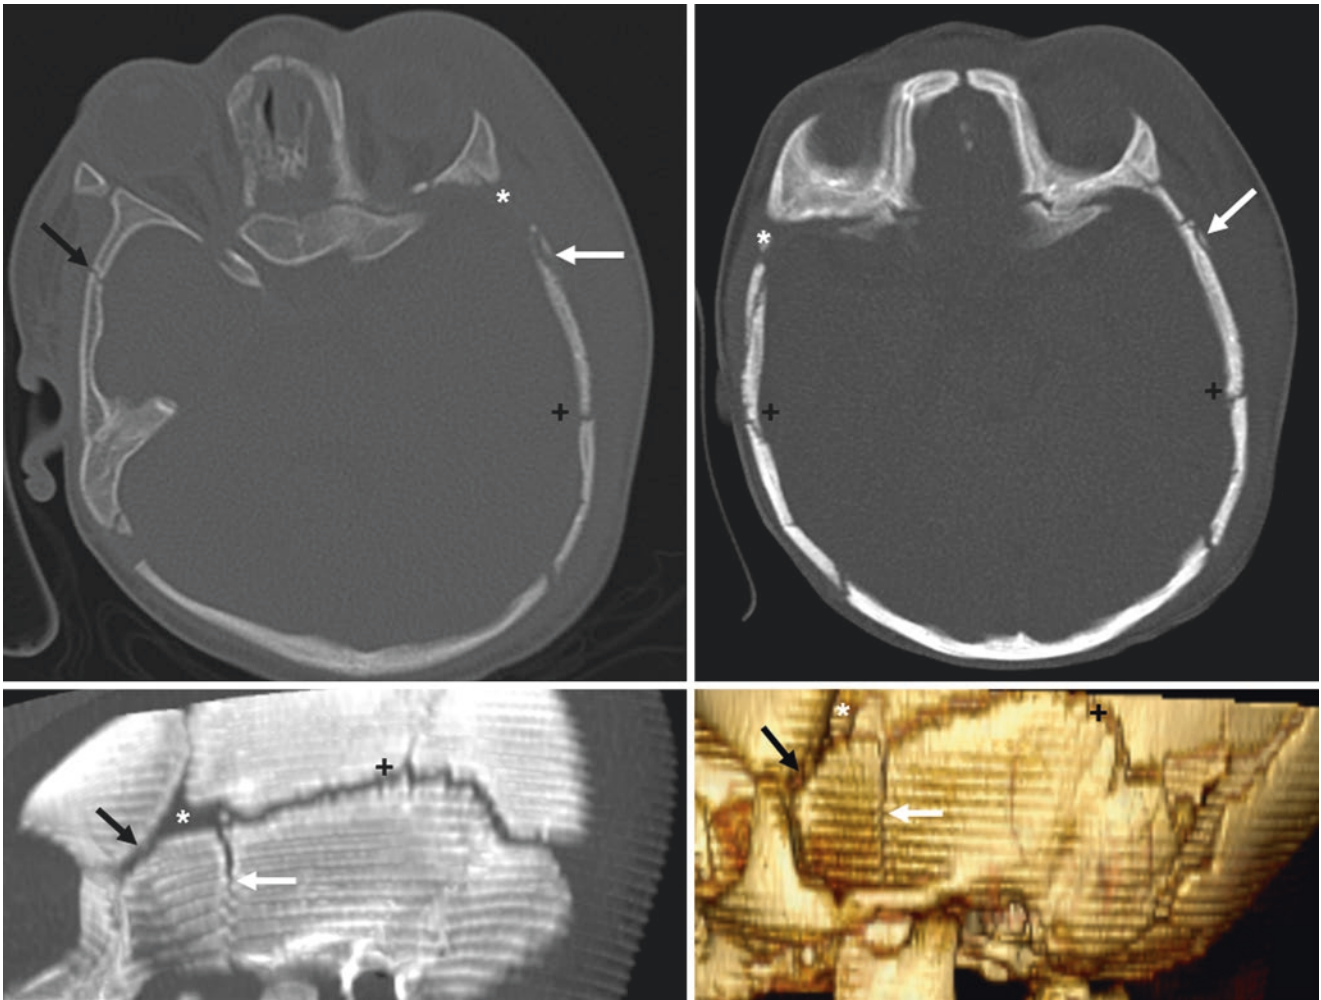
A 3 month old with left orbital and scalp swelling. The CT (top left) raised the question of fractures (white arrow). The patient had been obliquely positioned; axial (top right), sagittal MPR (bottom left), and three-dimensional reconstruction (bottom right, lateral view) images showed that these were simply symmetric frontosphenoidal
